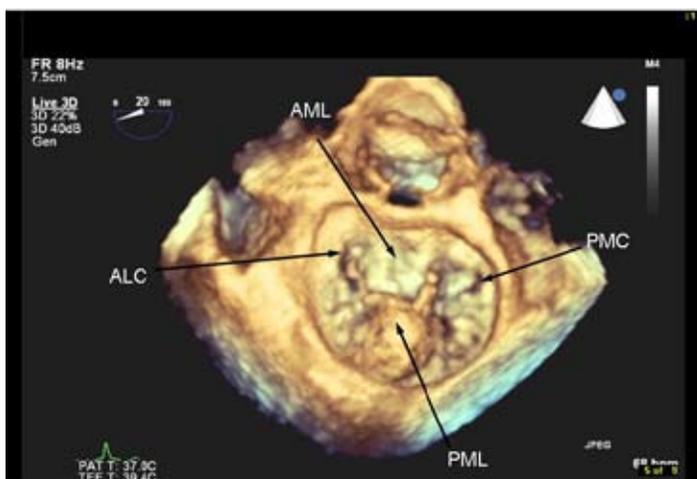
The *en-face* view of the mitral valve corresponding to the surgical view obtained by the real-time three dimensional transesophageal echocardiography. The P2 segment of the posterior mitral leaflet shows a prolapse and flail. PML = posterior mitral leaflet; AML = anterior mitral valve leaflet; ALC = anterolateral commissure; PMC = posteromedial commissure
